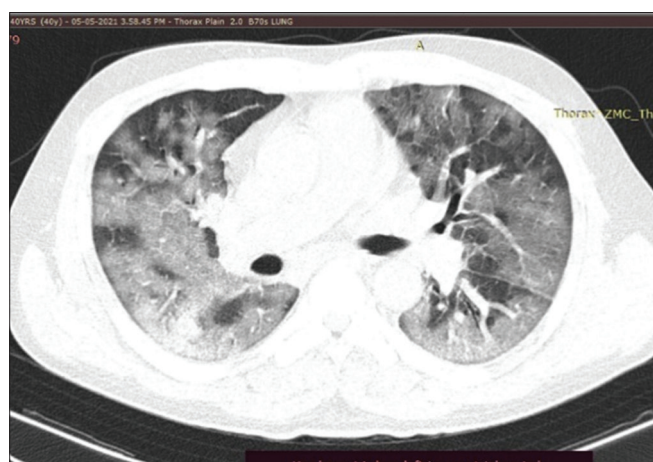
Baseline CT Chest showed crazy - paving pattern or a mixture of parenchymal lesions with involvement of all lobes in all the case series where Chest CT was performed
